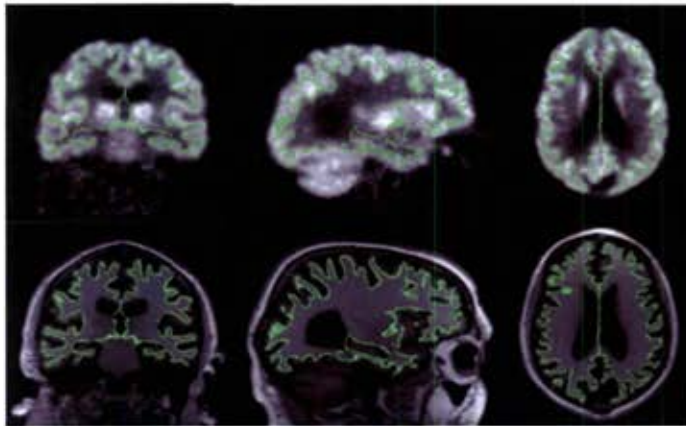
Coregistration of FDG PET and T1-weighted MPRAGE MRI scans shown in coronal, sagittal, and axial sections. The green line indicates the gray/white matter boundary. The FDG PET scans are on the top and the MRI scans are on the bottom. The images are from a normal aging 83 year old male.
